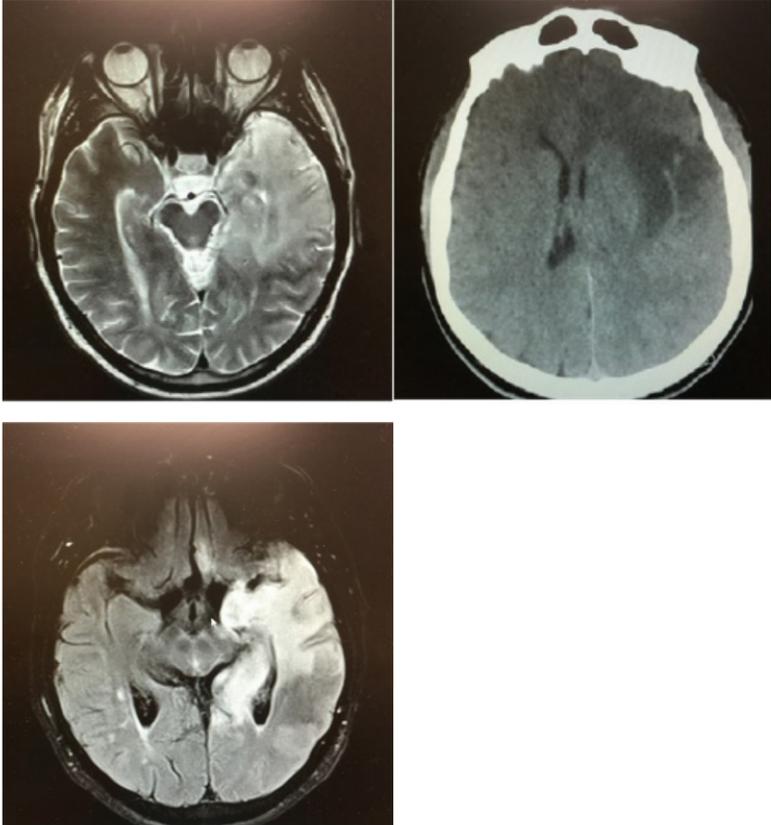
T2 weighted MRI scans of the brain. There is an area of increased T2/FLAIR signal involving the left temporal lobe, extending to involve the insular cortex superiorly, the medial left occipital lobe and posterior thalamus posteriorly and the posterior right frontal lobe anteriorly. There is associated mass effect with diffuse effacement of the sulci in the affected regions, midline shift to the right of up to 4 mm and partial compression of the left lateral ventricle.
